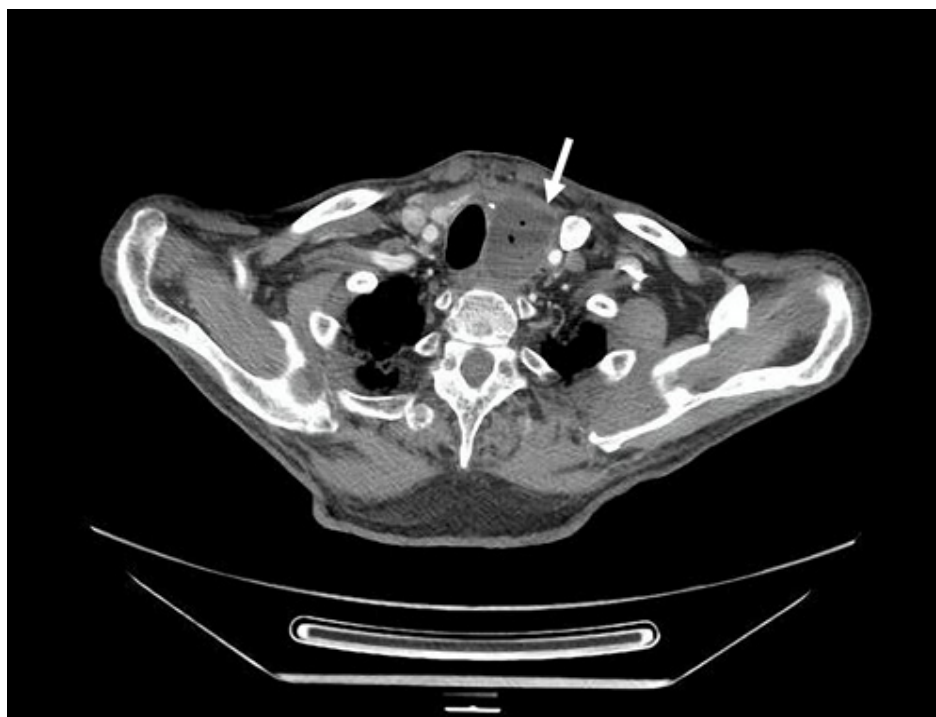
Computed tomography of the cervical spine revealing the left nodule pushing and causing pressure, posteriorly displacing the left common carotid artery and outwardly displacing the internal jugular vein.
